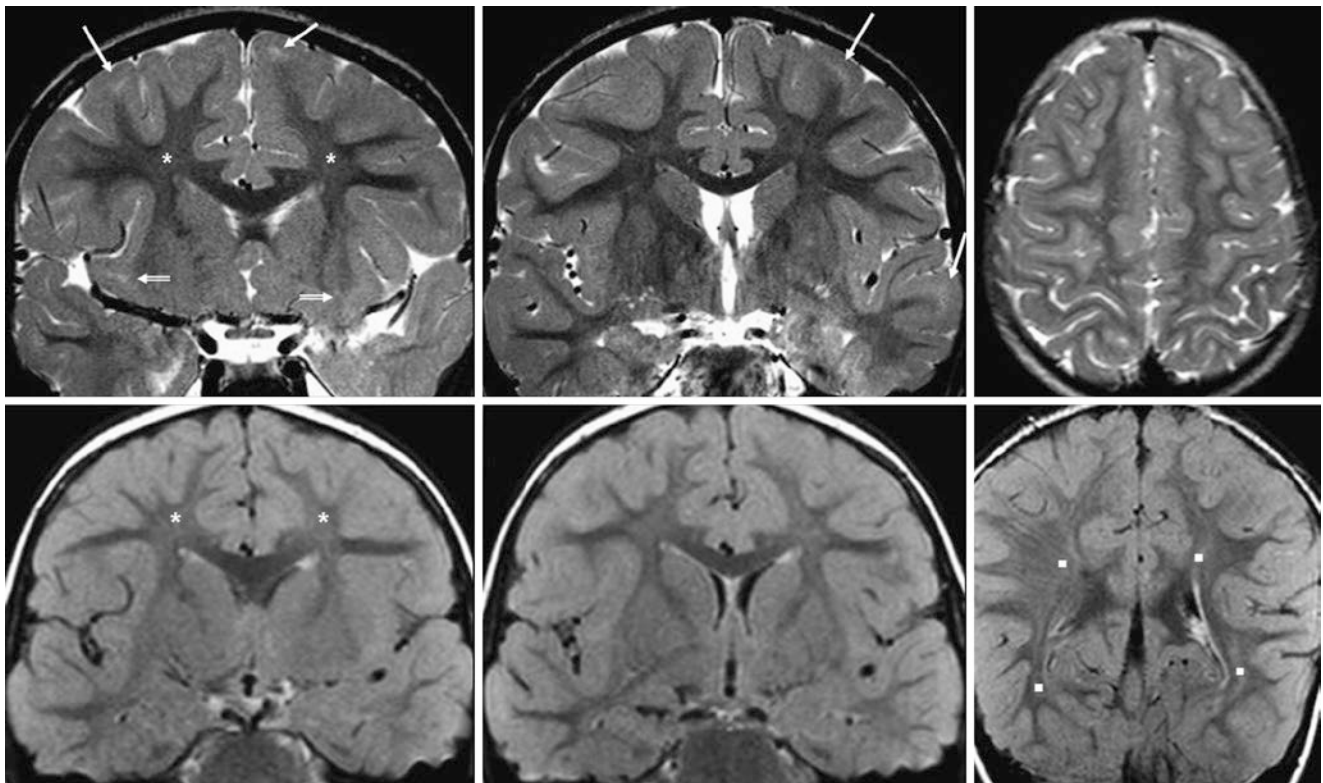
A 3.5-year-old with seizures. *Top row:* 3T MRI coronal SE T2WI (*left and middle*) depicts subtle, patchy regions of incomplete maturation of SCWM (*thin arrows*), not visible on axial SE T2WI (*right*). *Bottom row:* Such SCWM terminal zones are also not visible on 2D coronal FLAIR; note subtle, terminal zones of the PTWM (*squares*), SIWM (*beveled arrows*), and frontal PVWM (*asterisks*)
